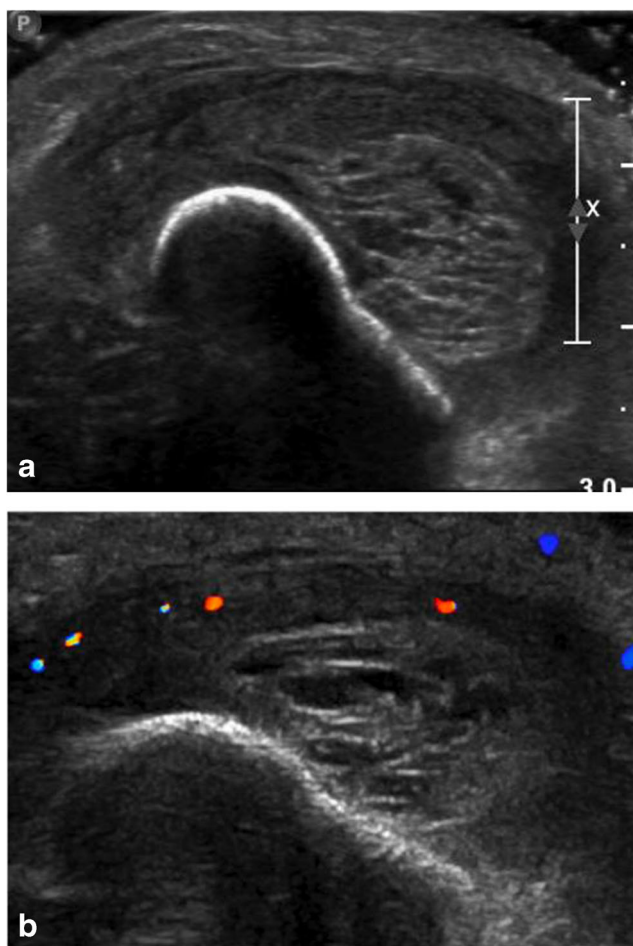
Axial (a) grayscale and (b) color Doppler ultrasound images of the right leg centered over the area of maximal swelling
